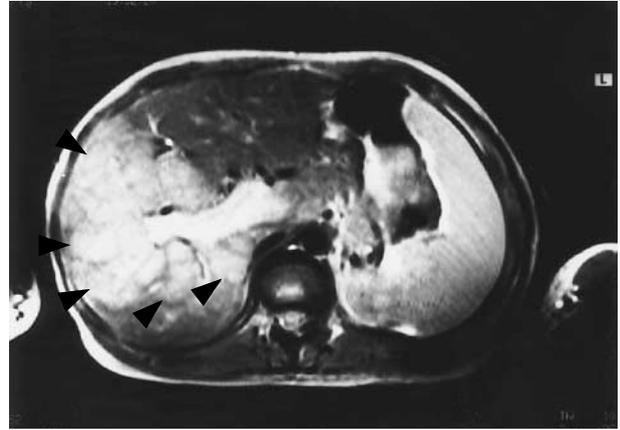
Initial Abdominal CT Scan in a 14-Year-Old Boy, Revealing a Multinodular Hepatic Tumor. The arrowheads show the limits of the tumor.
